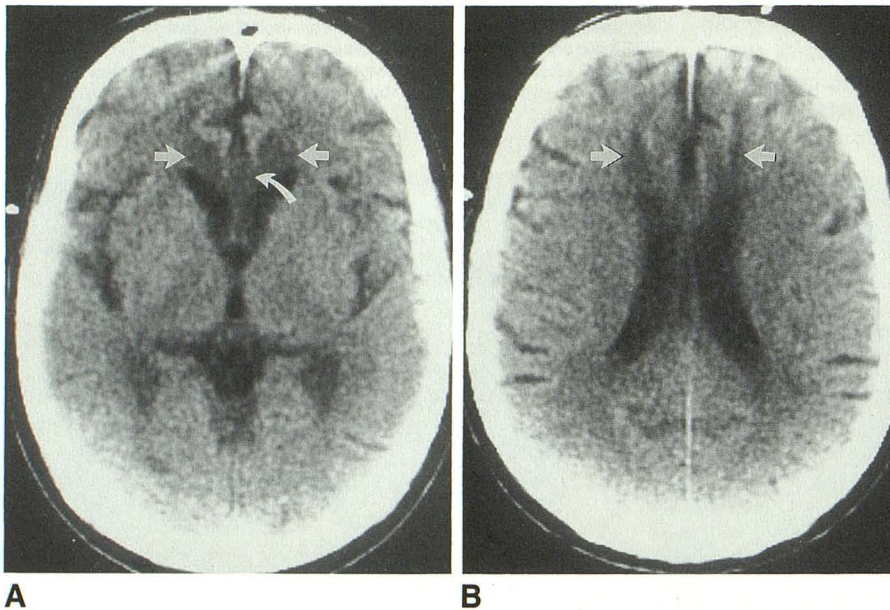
A and B, CT scans show new areas of decreased attenuation in medial frontal lobe cortex bilaterally (straight arrows) and in corpus callosum (curved arrow).
